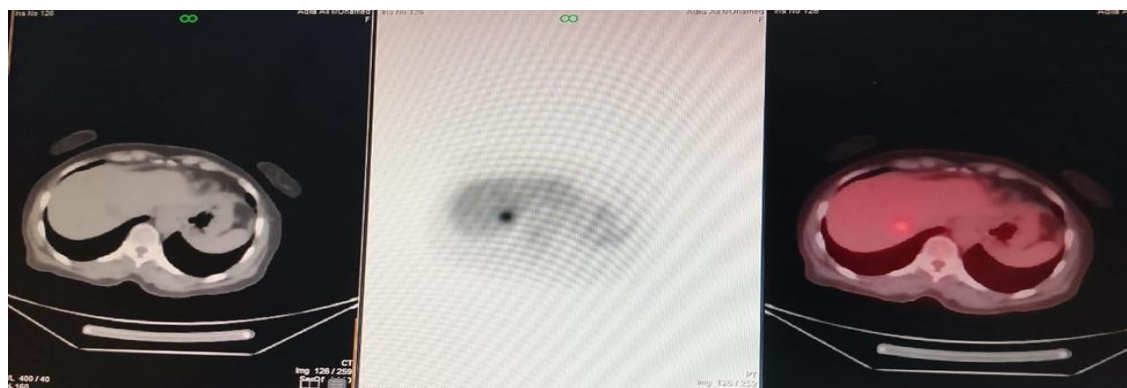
69 years female patient with cancer colon, PET CT revealed FDG avid hepatic focal lesion +/-25mm with SUV max 4.12
